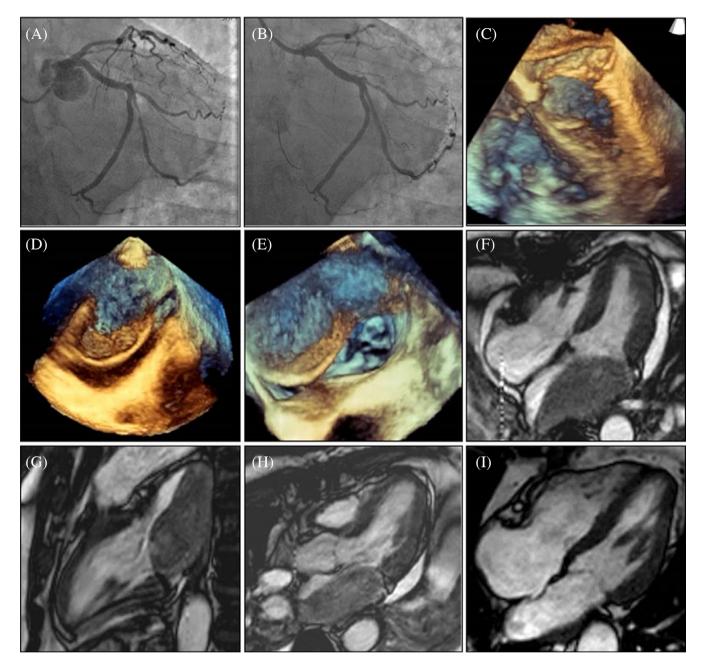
Culprit marginal obtuse branch lesion (A). Left atrial perforation (B). 3D TEE views of the left atrial dissection with mitral disturbance (C–E). CMR of the LatD in the acute phase (F–H). Follow-up CMR imaging confirming the healing of the atrial dissection. Angiography, 3D Echo, and CMR-Cine are available in the supporting information (Videos S1, S2, S3, S4, S5, S6, and S7). CMR, cardiac magnetic resonance; LatD, left atrial dissection; TEE, transesophageal echocardiogram [Color figure can be viewed at wileyonlinelibrary.com]
